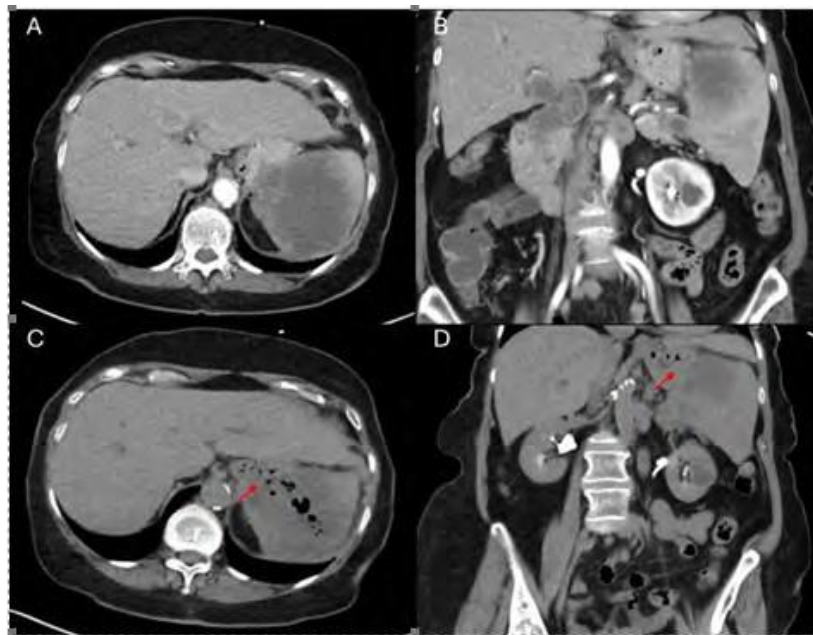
Abdominal CT scans. (A) Axial view and (B) coronal view of initial abdominal CT with intravenous contrast 1 month prior to admission without any sign of fistula. (C) Axial view and (D) coronal view of fistula (indicated by red arrow) in CT without contrast performed on admission.
